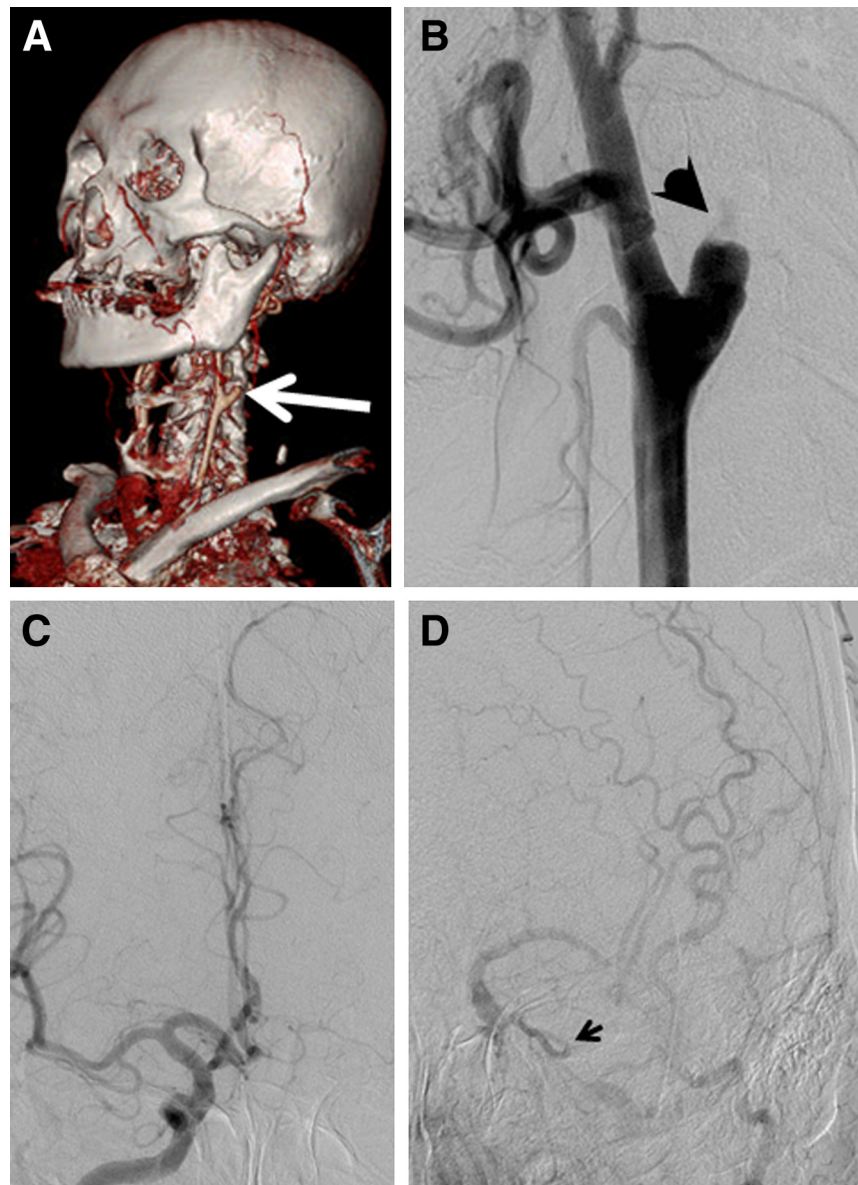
Computed tomographic angiography on admission showed left cervical internal carotid artery (ICA) occlusion (large arrow) (A). Digital subtraction angiography on admission suggested presence of left cervical ICA wall dissection with retention of contrast medium in possible false lumen (arrowhead) (B). Right ICA supplies no apparent cross flow to left ICA circulation (C). Left ICA-middle cerebral artery system appears via ophthalmic arterial collateral flow (small arrow) (D).
